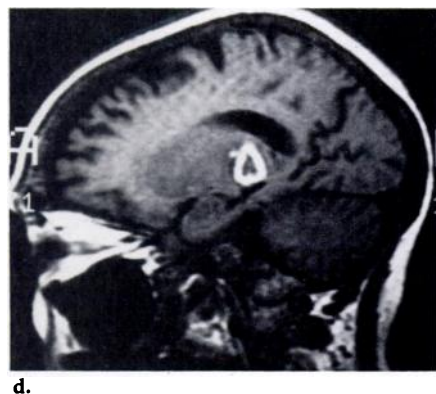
Hypertensive left thalamic ICH in a 67-year-old woman. (a) Unenhanced CT scan within 12 hours of hemorrhage. (b) Sagittal T1-WI within 24 hours (TR, 600 msec; TE, 20 msec). The ICH (arrow) is isointense to gray matter. (c) Coronal T2-WI (TR, 2,000 msec; TE, 60 msec). The ICH is markedly hypointense to both the parenchyma and the converted cerebrospinal fluid. The perihematoma hyperintensity (arrow), not present on the T1-WI, is consistent with edema. (d) Sagittal T1-WI after 6 days (TR, 800 msec, TE, 20 msec). Peripheral hyperintensity has appeared.
